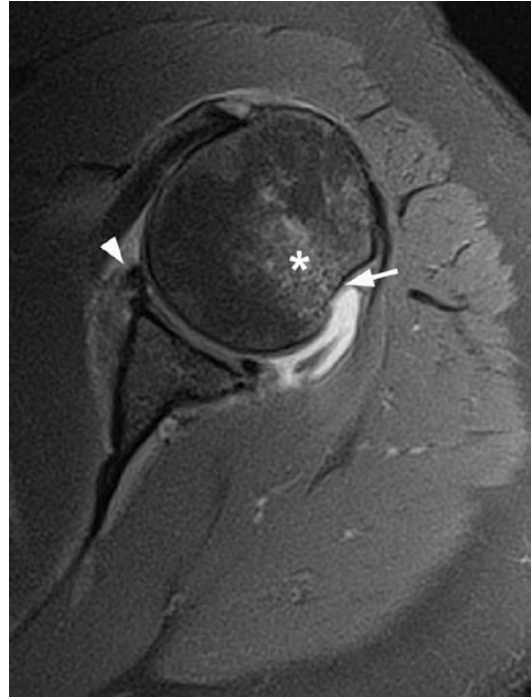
Hill-Sachs lesion following anterior shoulder dislocation. Axial PD fs FSE MR image shows focal impaction of the posterior humeral head (arrow) with underlying edema-like marrow signal (asterisk) from recent contusion and the torn anterior labrum (arrowhead)
